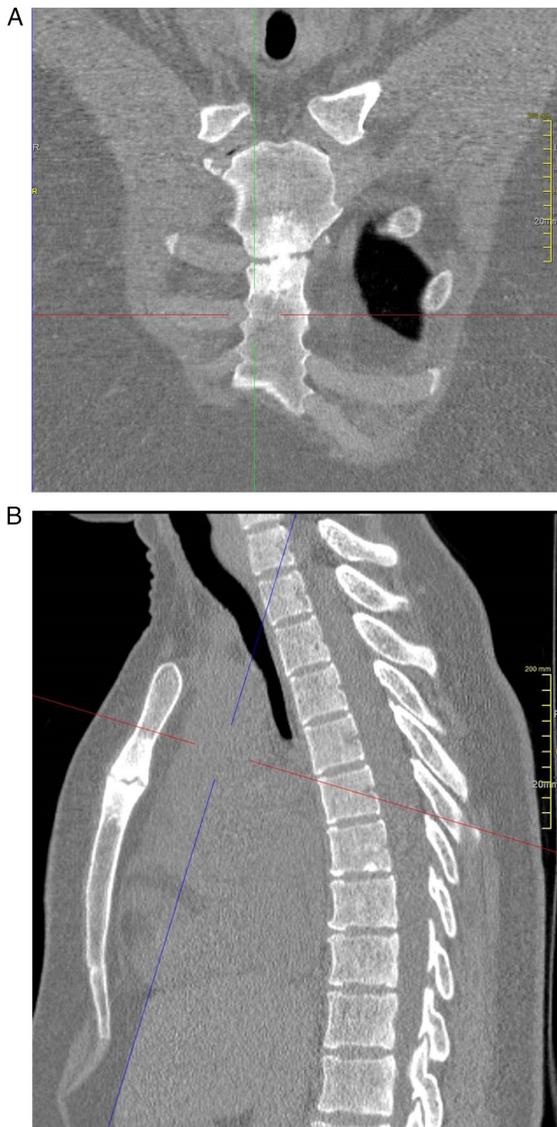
Computed tomography images in (A) coronal and (B) sagittal planes at diagnosis, showing sclerosis, irregularities and erosions of the manubriosternal joint (scale bar, 200 mm).
